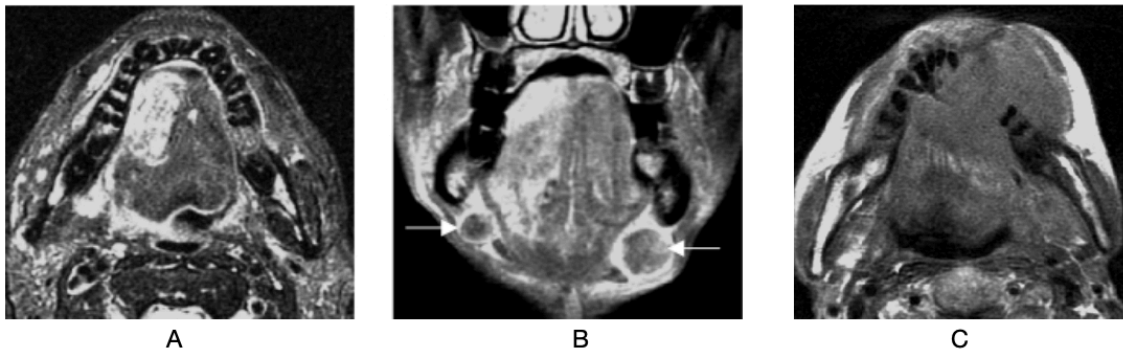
MRI studies of tongue cancer. A. Axial T2 weighted fat-suppression image shows a right-sided tongue cancer extending over 5 mm from the lateral margin of the tongue; B. Coronal T2 weighted fat-suppression image shows bilateral submandibular lymphadenopathy (arrows), a result of the lymphatic drainage pathways of the inner two-thirds of the oral tongue; C. Axial T1 weighted image shows a tongue cancer with mandible invasion. Extracted from (27,28).
